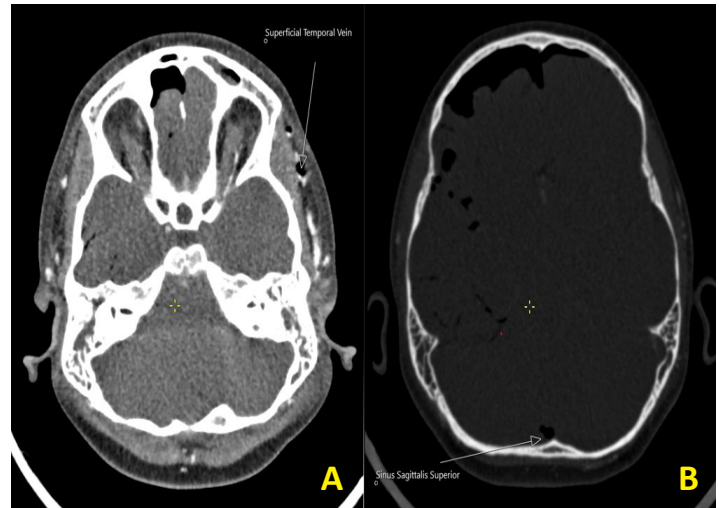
Parenchymal window (a) and bone window (b) enhanced cranial CT showing air densities in the superficial temporal vein (a) and sinus sagittalis superior (b).
